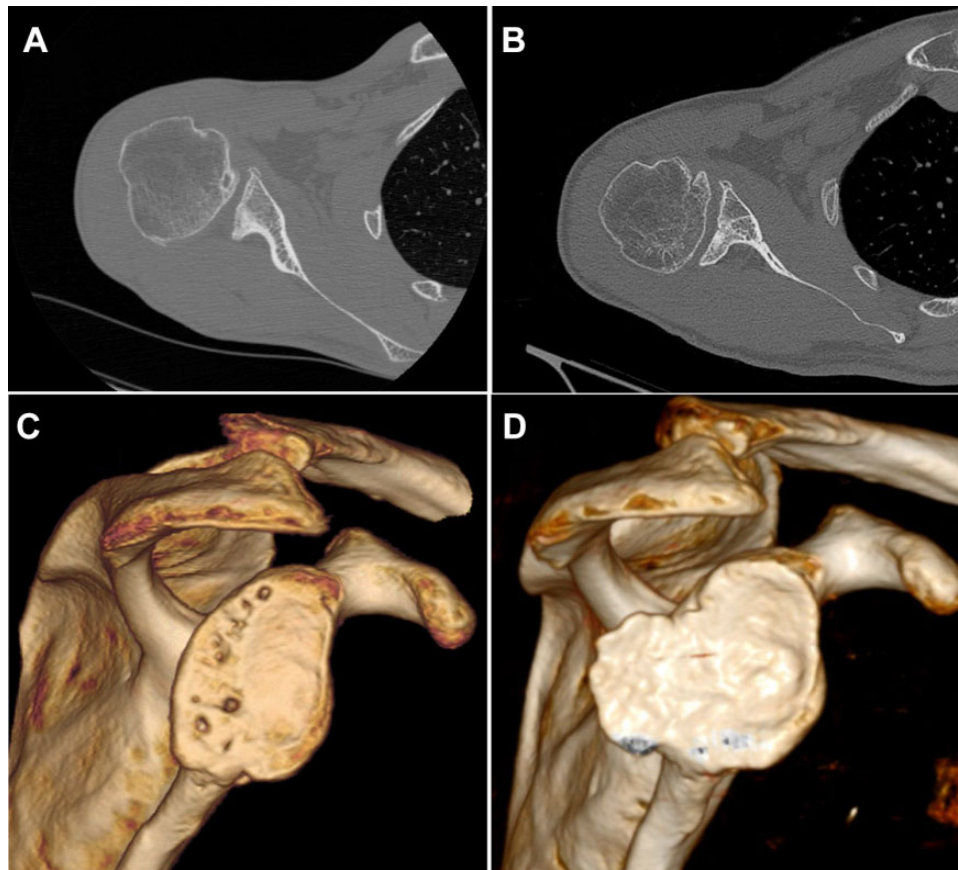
(A) Preoperative axial computed tomography scan and (C) 3-dimensional en face view of a 46-year-old male patient with a painful right shoulder (visual analog scale for pain, 6) and failed posterior Bankart procedure 4 years before arthroscopically assisted iliac crest bone grafting. This patient showed preoperative glenoid retroversion of 30° and humeral posterior subluxation with a scapulohumeral index of 80%. (B, D) Postoperatively, at 9-year follow-up, the patient showed decreased glenoid retroversion of 17° and a scapulohumeral index of 67%. This patient showed high-grade osteoarthritis preoperatively. Nevertheless, he had a good clinical outcome, with a Constant score of 95.
